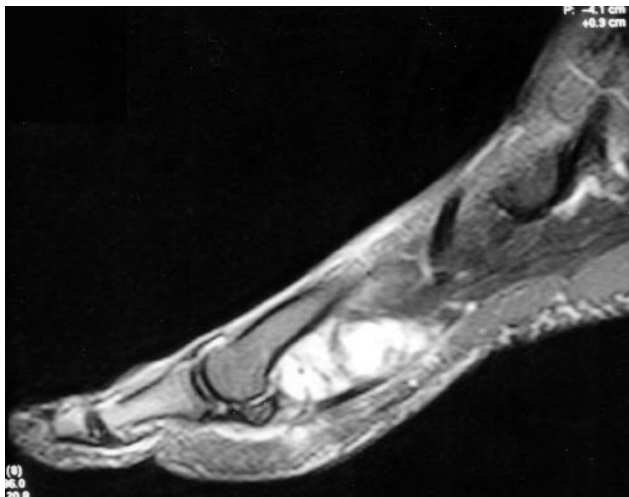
T2 weighted sagittal MRI scan of right foot showing a lobulated mass with moderately high signal intensity beneath the first metatarsal and proximal to the first MTP joint.
